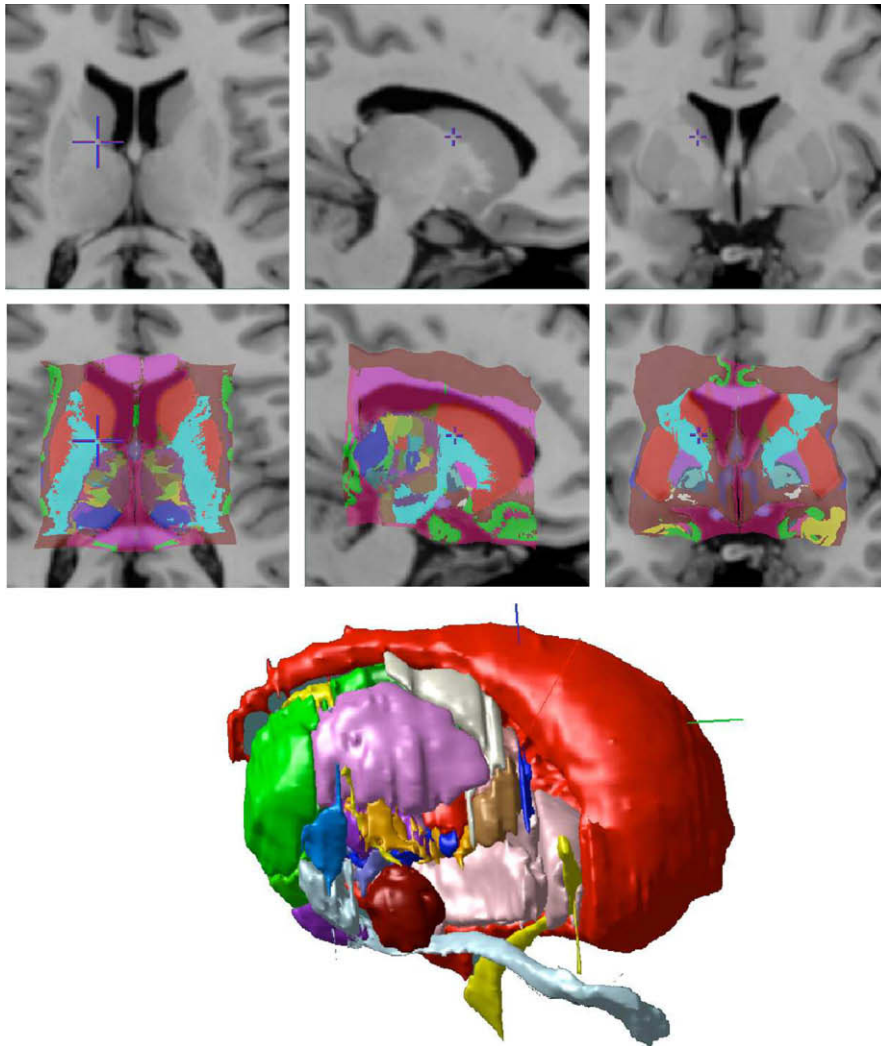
(From top to bottom) Axial, sagittal, and coronal views of the Colin27 MRI template and the atlas warped to the Colin27 template. The 3D geometric atlas is shown on the bottom of the figure. The top two rows of this figure also demonstrate the extents of the ROIs used for atlas warping Methods B and C.
